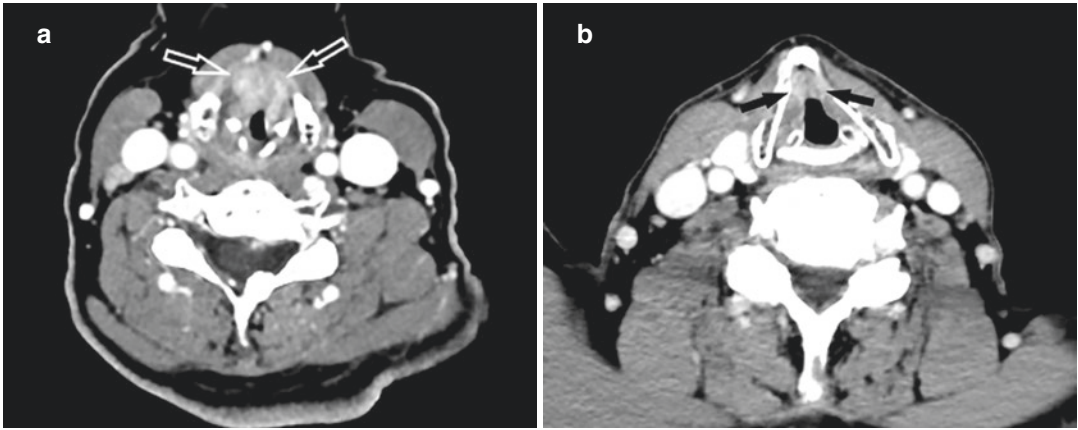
Laryngeal tuberculosis presenting as a vocal cord mass mimicking cancer. (a) Axial contrast-enhanced CT image shows a heterogeneously enhancing mass at the anterior false and true vocal cords bilaterally (open arrows). The mass has the same appearance as a mass due
